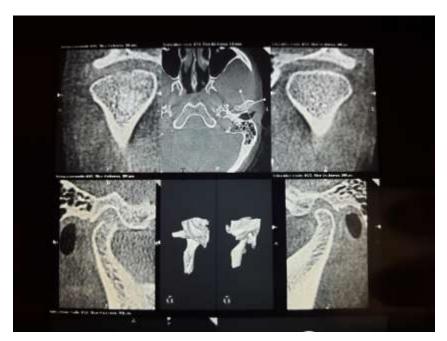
CBCT showing erosion in the articular surface in superior surface of right condyle
